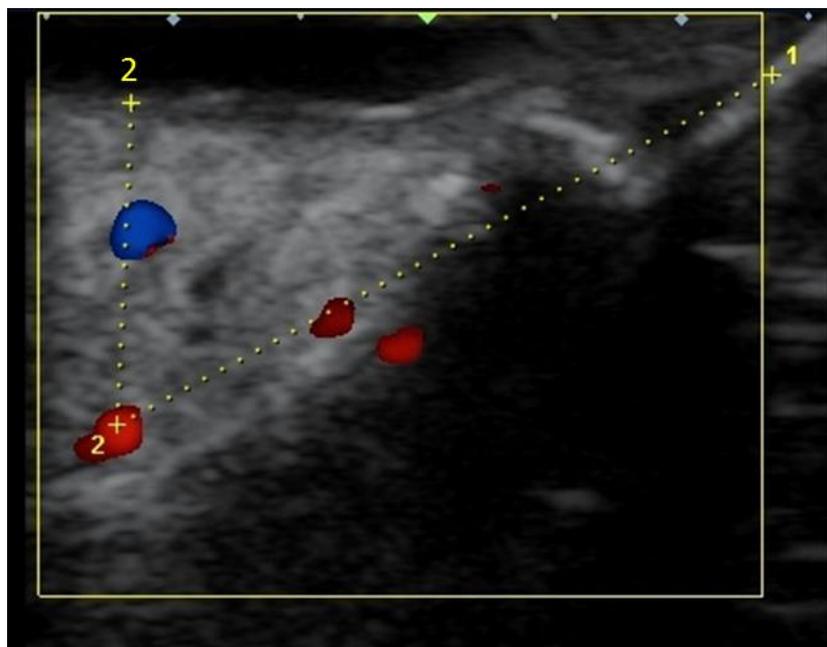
Measuring of Ultrasound image. (1) GM-GPA, (2) PG-GPA
